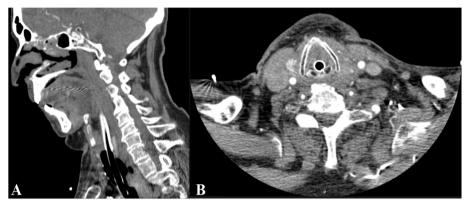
CT scan of retropharyngeal hematoma after 8 h of compression with the Blakemore balloon, with the patient still intubated. Note the absence of spot-sign
